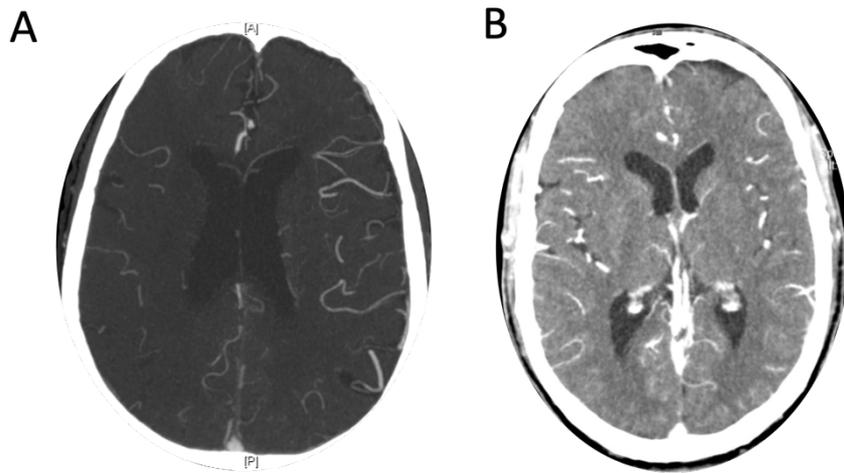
Example of the poor (A) and good (B) collateral flow imaged with CTA (graded according to Tan et al., 2009). In each sequence, ischemic lesion is present in the right hemisphere; (A) Poor collateral supply ipsilateral to the lesion, <50% of occluded MCA territory is supplied (score = 1); (B) Good collateral supply of >50% of the occluded MCA territory (score = 2).
